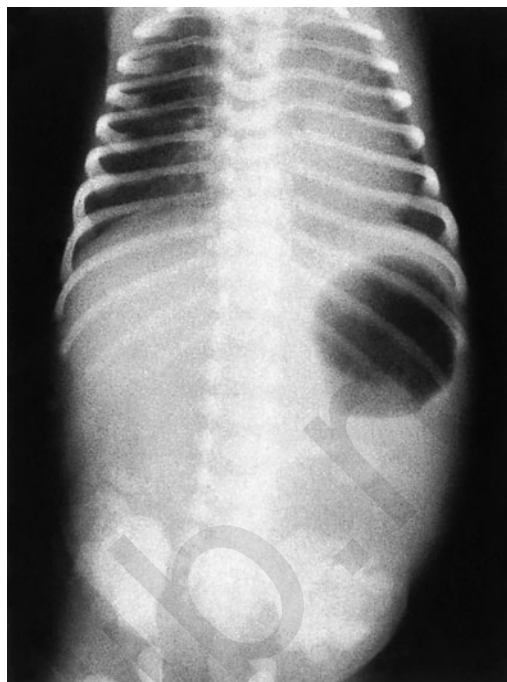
Abdominal x-ray showing absence of air beyond the stomach.
